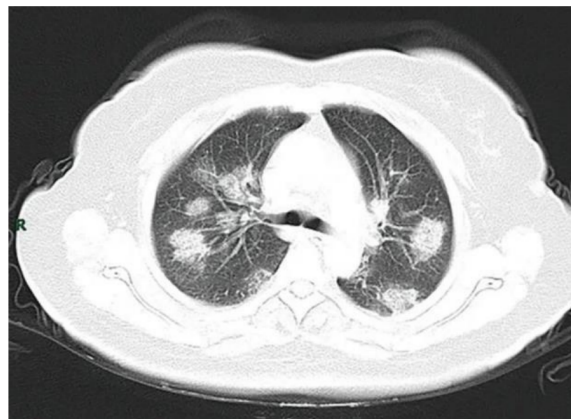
A CT scan of a patient with COVID-19 shows lesions (bright regions) in the lungs
